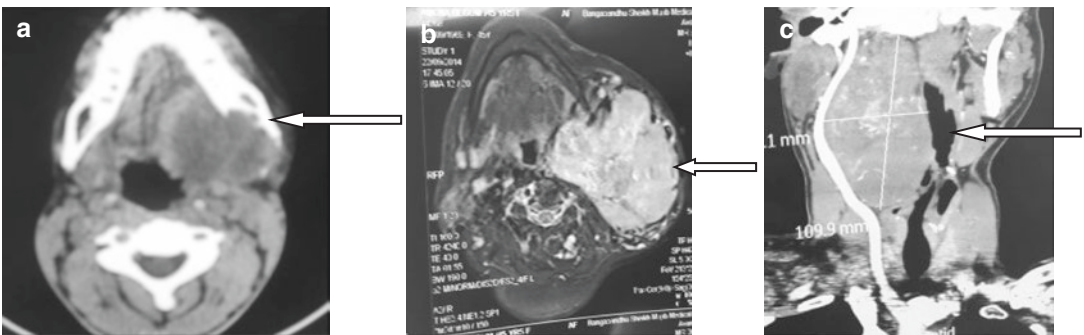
(a–c) Imaging of parapharyngeal tumors (different patients). (a) CT scan (malignant tumor). (b) MRI. (c) CT angiogram
